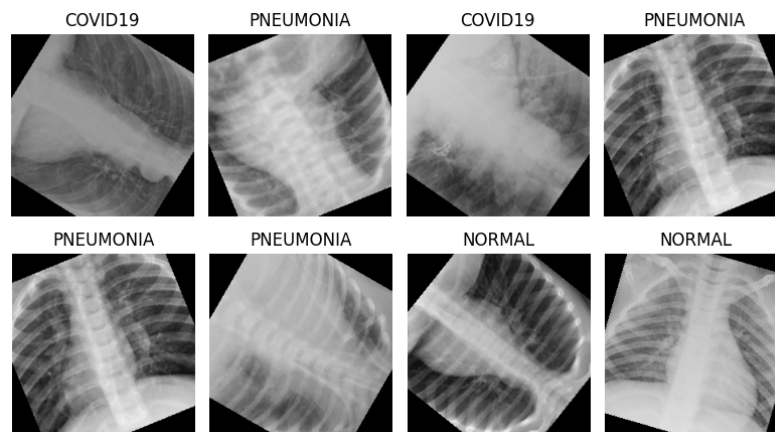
Images from the Chest X-Ray dataset after data augmentation
